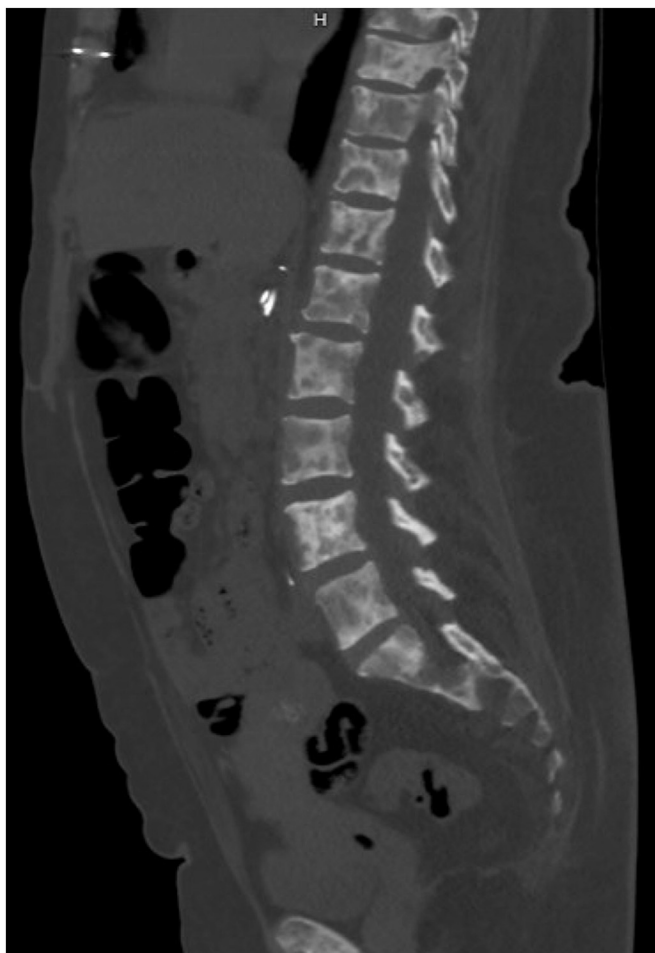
Mixed lucent and sclerotic lesions involving the vertebrae noted from CT scan. CT = computed tomography.
